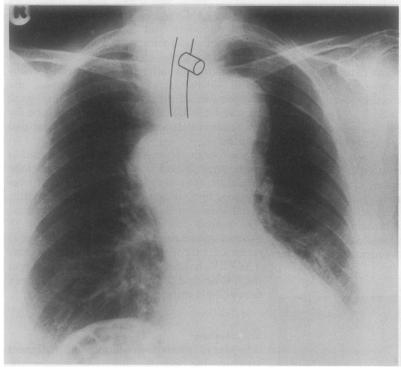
Chest radiographs of a patient (No 6) with squamous cell carcinoma of the left upper lobe bronchus showing (a) displacement and compression of the trachea by the tumour (outlined) and insertion of a Montgmery type silicone T tube after left upper lobectomy (position of T tube outlined).
